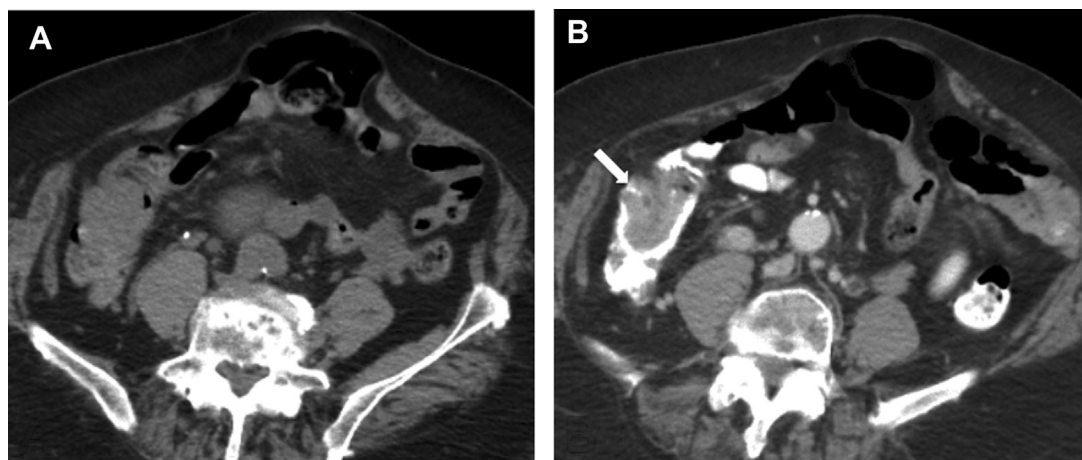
Cecal cancer. An 81-year-old woman with failure to thrive. Axial image (A) from a CT performed without oral or intravenous contrast shows no detectable colonic abnormality. Image (B) from repeat CT examination performed a few days later with oral and intravenous contrast clearly shows a large cecal mass (*arrow*), confirmed to be adenocarcinoma on colonoscopy.
